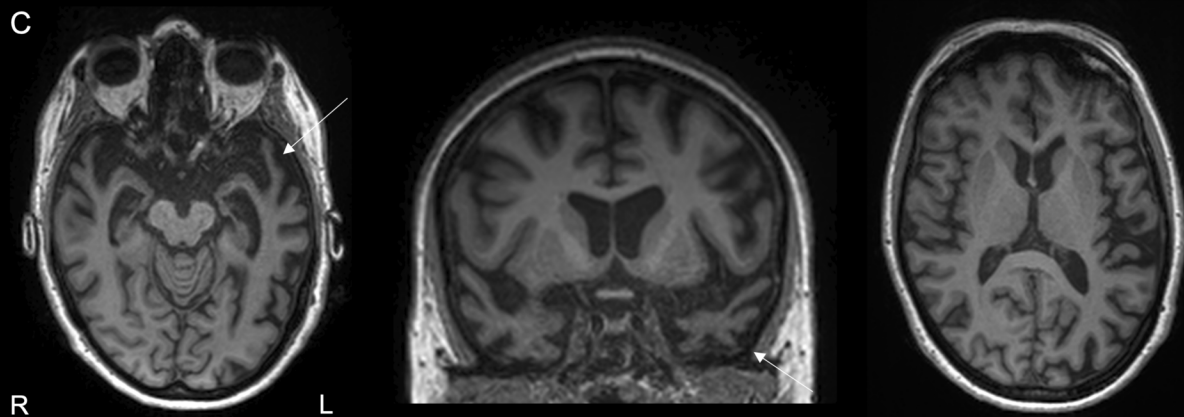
MRI and ¹⁸FDG-PET studies in patient #01. A: cortical atrophy prevailing in the left anterior temporal lobe (arrows) at age 43, 4 years after onset. B: asymmetric temporo-polar hypometabolism, prevailing on the left side, at the same age. C: progression of atrophy in left temporal regions (arrows), and extension to the contralateral side and frontal cortex at age 46, 7 years after onset.
